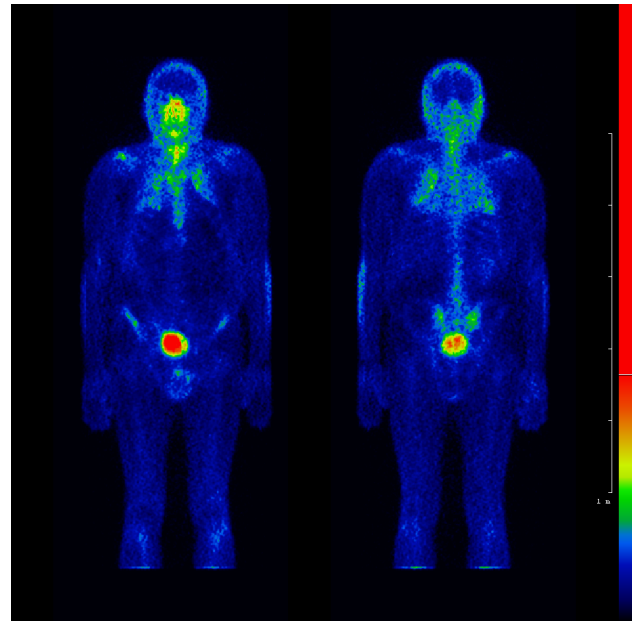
Artificial planar anterior (left) and posterior (right) image pairs generated from a whole body stitched and reconstructed SPECT. Note that no stitching regions can be discovered on the image pairs.
